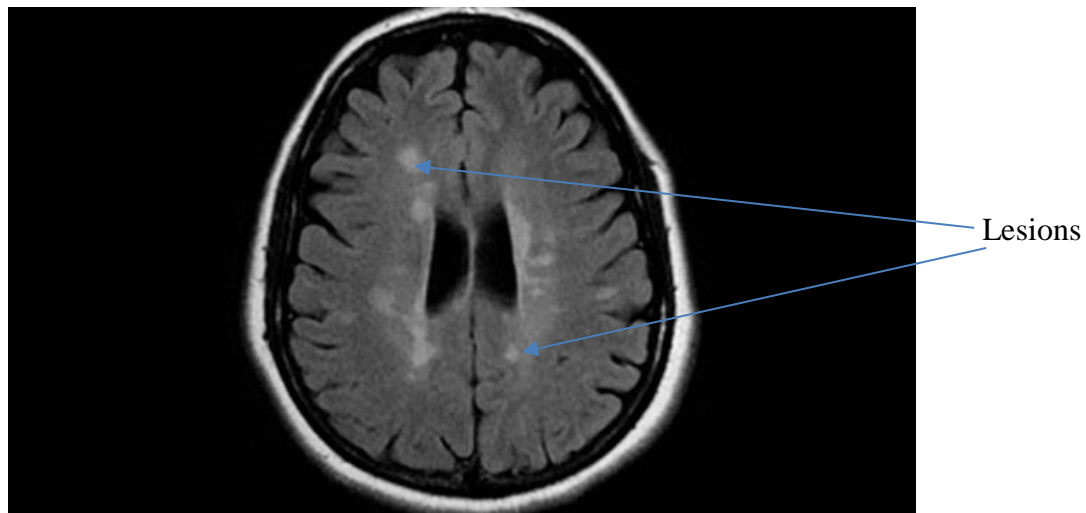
Brain MRI showing active lesions
